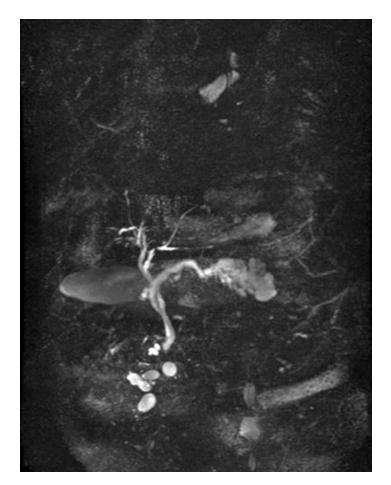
MRI image of a main duct IPMN
